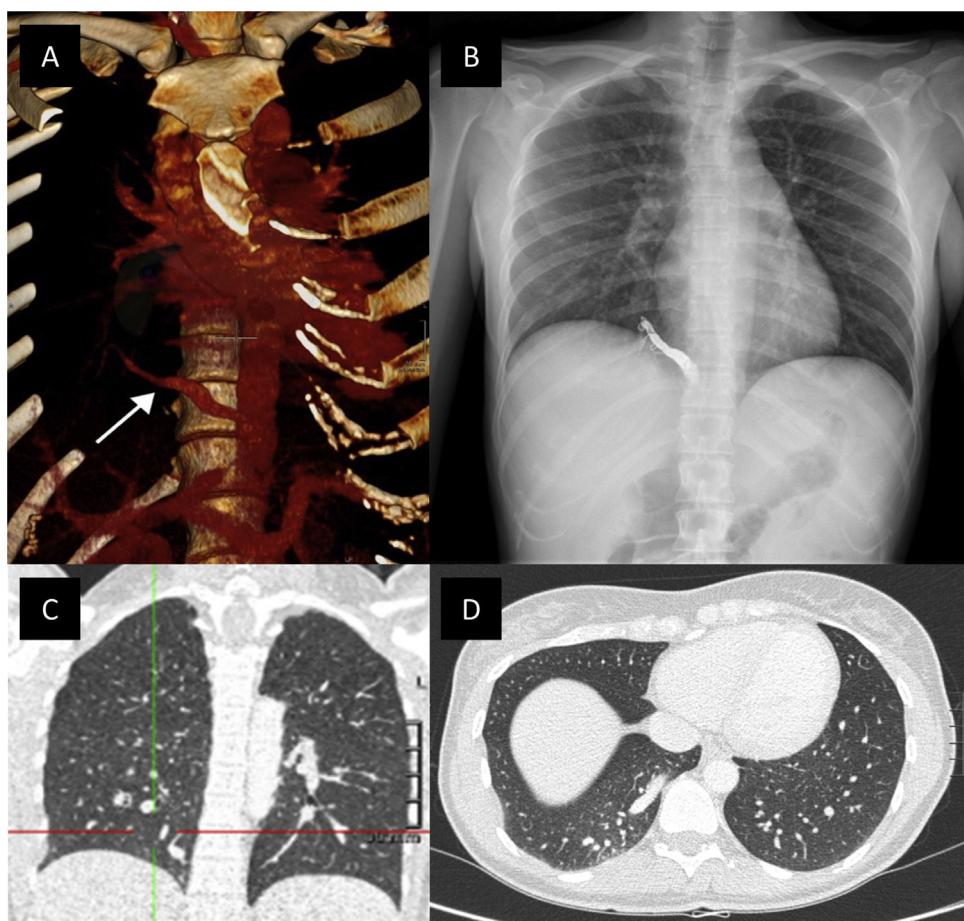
(A) Reconstruction of thoracic CT. Anomalous systemic artery arising from the abdominal aorta (white arrow). (B) 3-Month-follow-up with chest X-ray show the coils in the anomalous artery in the RLL. (C and D) Anomalous systemic artery arising from the abdominal aorta supplying a normal lung parenchyma.
